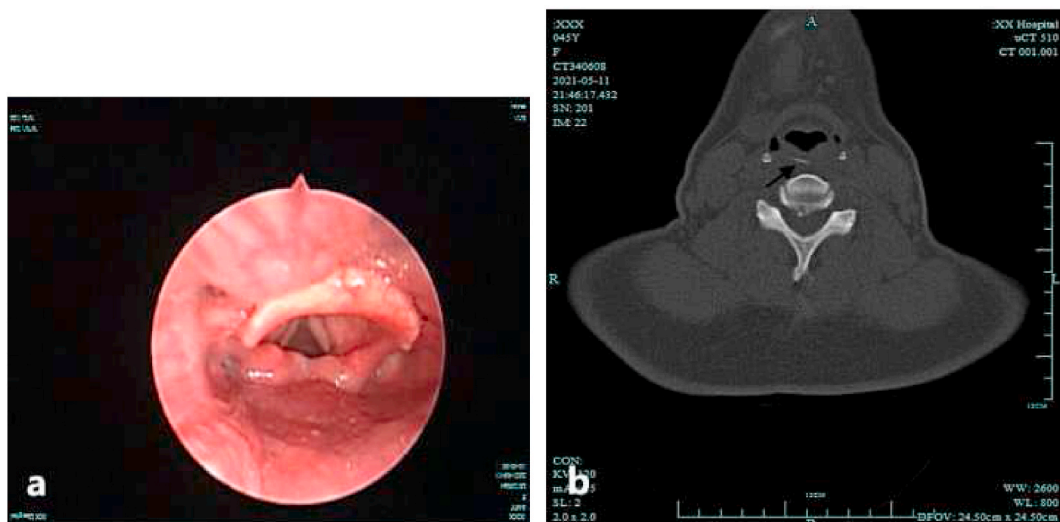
a. No fish bone found; b. Throat computed tomography (CT) shows a fish bone (black arrow).
